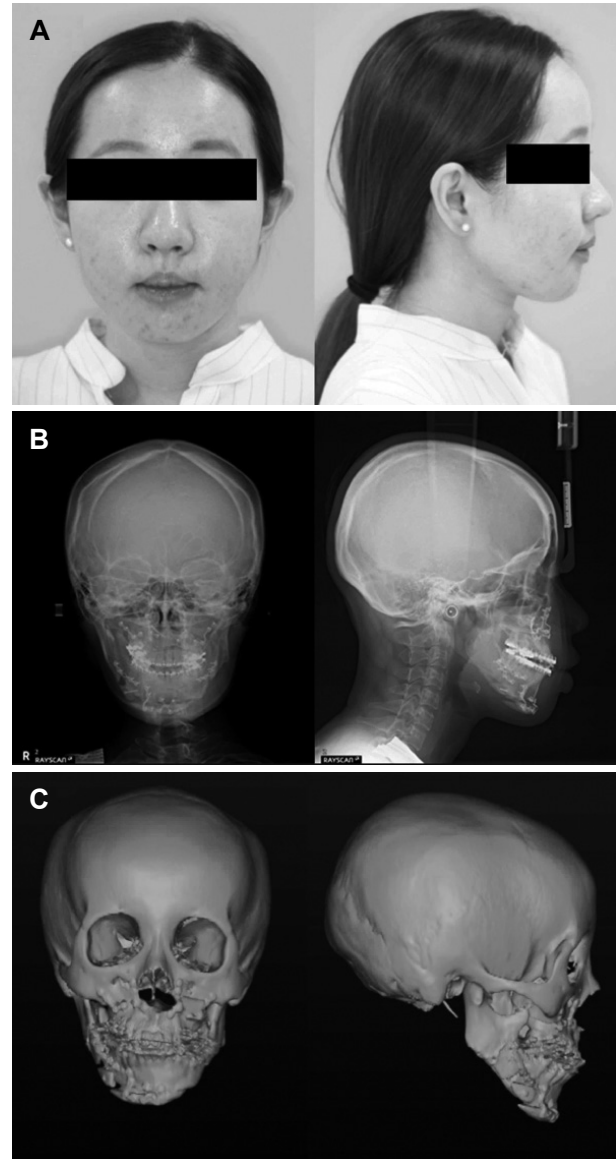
After surgery facial asymmetry is corrected (A) Facial photographs (B) Cephalometric radiographs (C) 3D virtual skulls.
